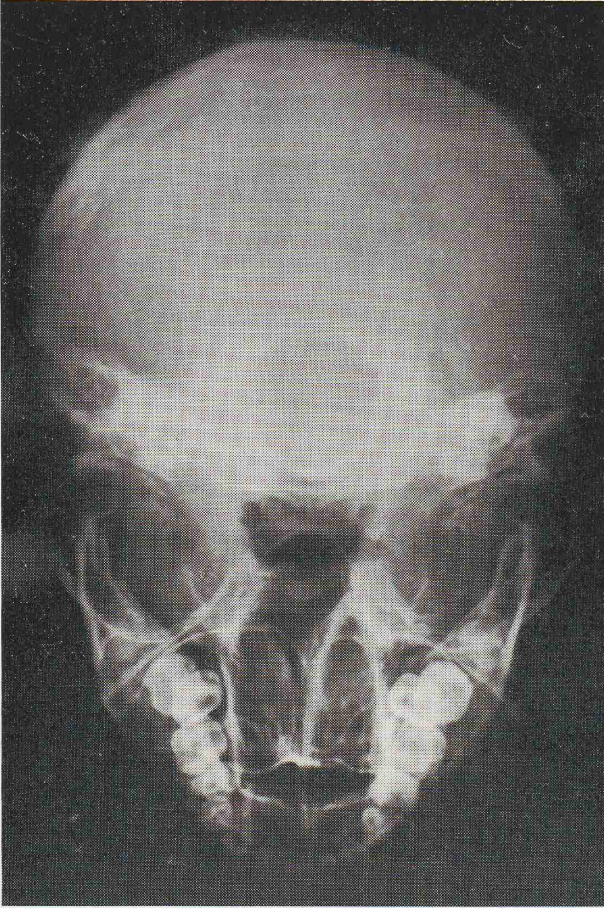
Radiograph of the cranial base showing osseous atresia of the right choana.
